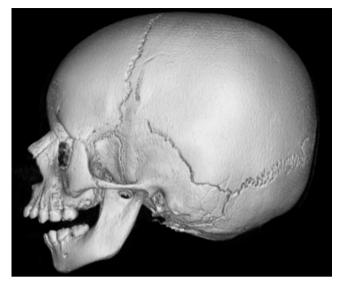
Patient with Pierre Robin sequence. Three-dimensional reconstructed image from CT images shows retrognathia
